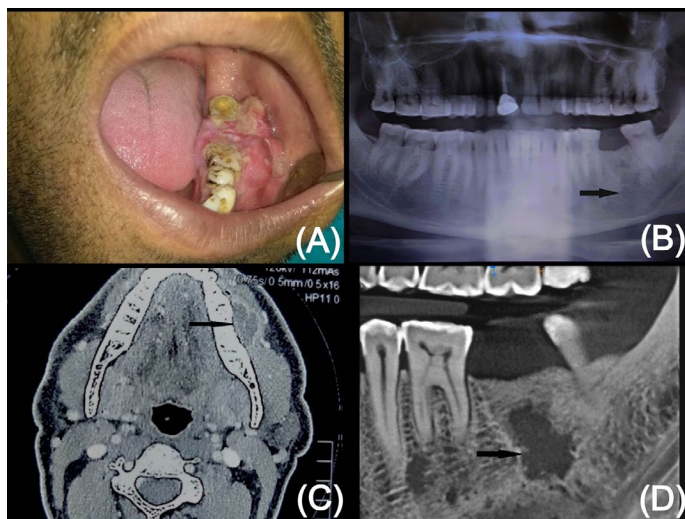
(a) Intraoral picture of patient showing ulcerated swelling present over gingiva in relation to 36-38 region (b) Orthopantomogram showing mild radiolucency (arrow) present in relation to 37 region (c) Contrast enhanced computed tomography image showing a soft tissue lesion present in left gingivobuccal sulcus (arrow) abutting the alveolar process in 36-38 region (d) Cone beam computed tomography image showing bone involvement (arrow)
